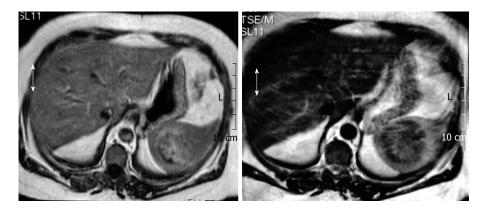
Magnetic resonance imaging shows a mass of 6 cm in diameter. Axial T1W image shows well circumscribed solid and heterogeneous intrasplenic mass. It might seem to have an excentric scar although calcification could also be possible. It is difficult to discern by magnetic resonance imaging.
